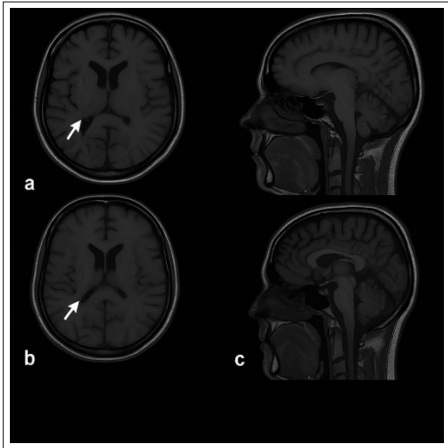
T2-Weighted MRI Brain Images Demonstrating Bilateral Parieto-Occipital Hyperintensities and Pontine Involvement
